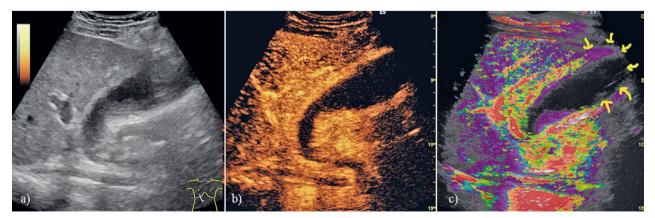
Ischaemic acute cholecystitis. Ultrasonographic exploration in grayscale (a), arterial CEUS (b), and parametric analysis of CEUS exploration (c). Lack of signal in the fundic region (arrows).
